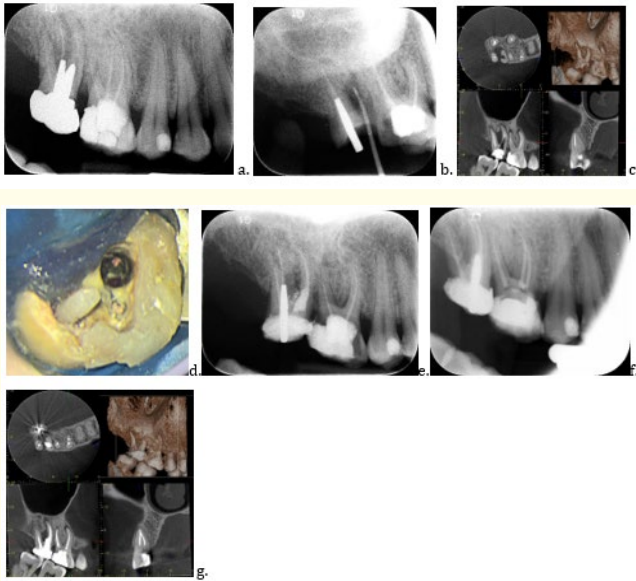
a. Preoperative radiograph b. Sinus tract origin radiograph c. Preoperative CBCT d. Intraoperative image showing site perforation e. Postoperative radiograph 17 f. Postoperative radiograph 16 g. 7 months follow-up CBCT.
